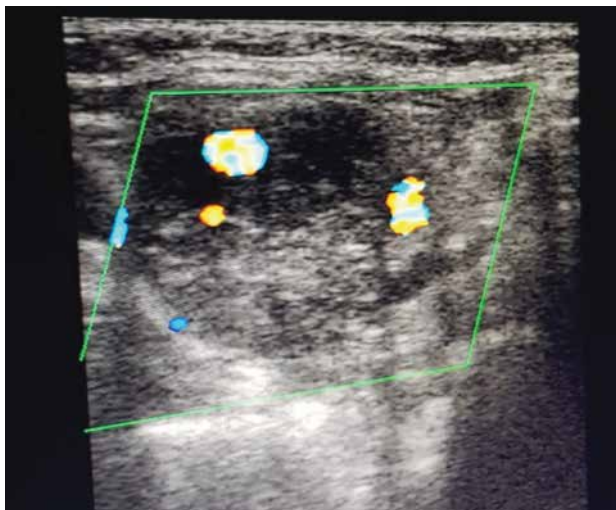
Color doppler showing splaying of ICA and ECA
